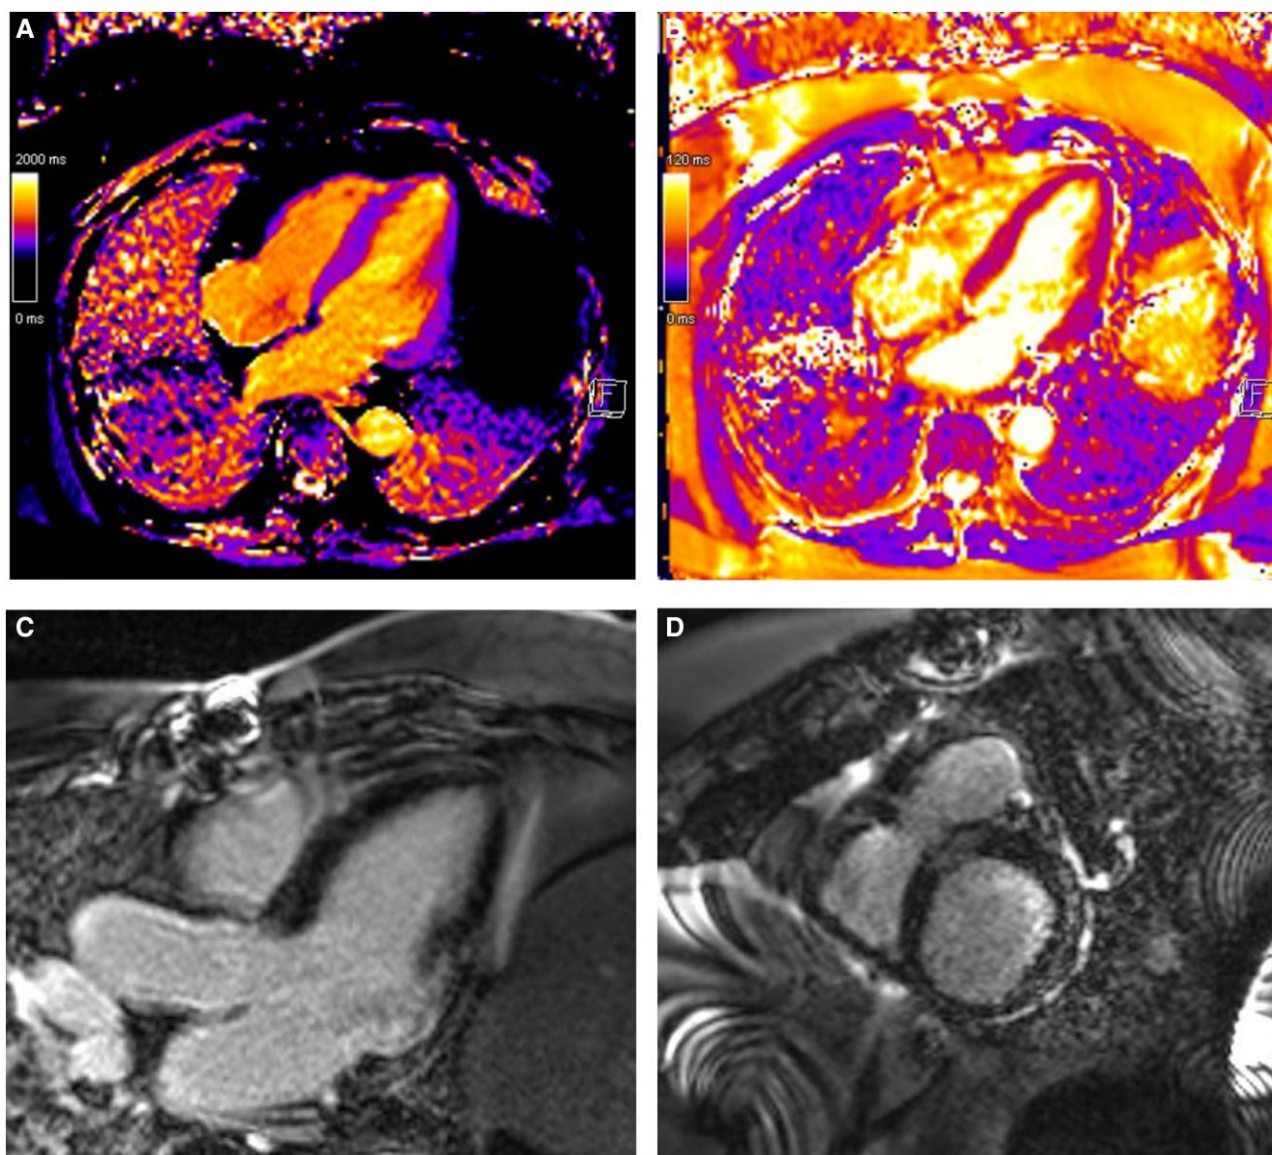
Cardiac MRI demonstrating normal global native myocardial T1 (A) and T2 (B) values with no regional variation. This study revealed normal left ventricular size with low-normal left ventricular ejection fraction (51%) with a previous infarcted territory in the basal inferior and basal posterior segments as demonstrated by akinesis and late gadolinium enhancement in the three-chamber (C) and short axis (D) late gadolinium series.
